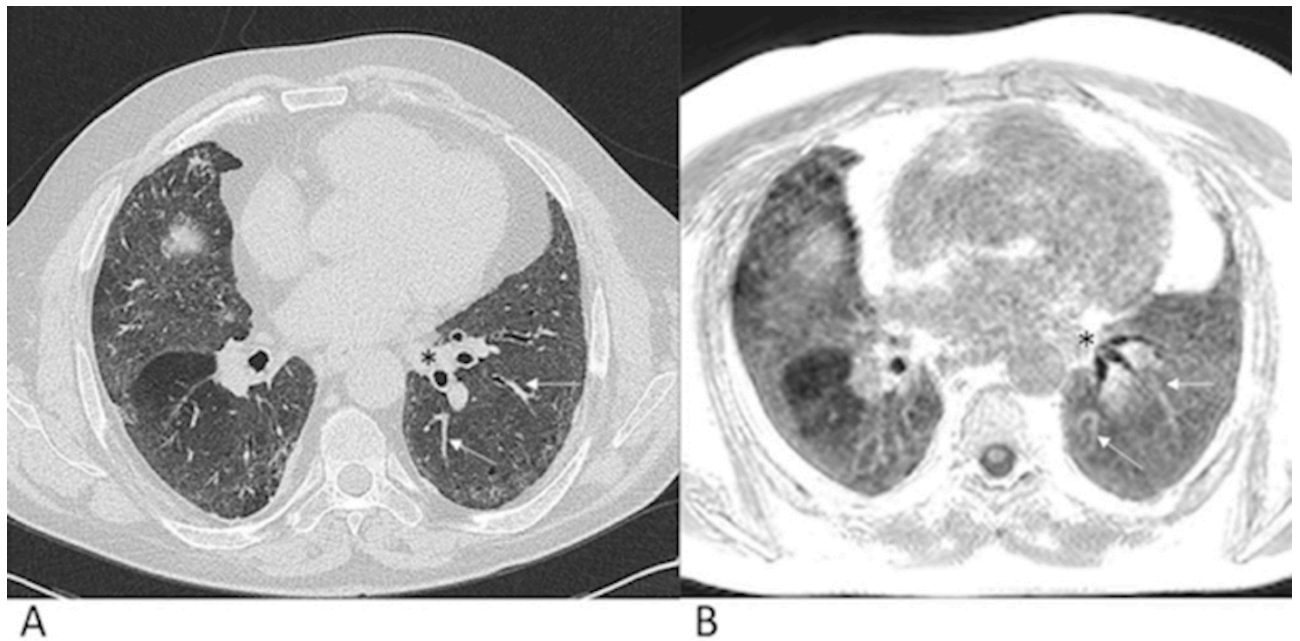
CT and UTE sQA SSc-ILD extent analyses.
